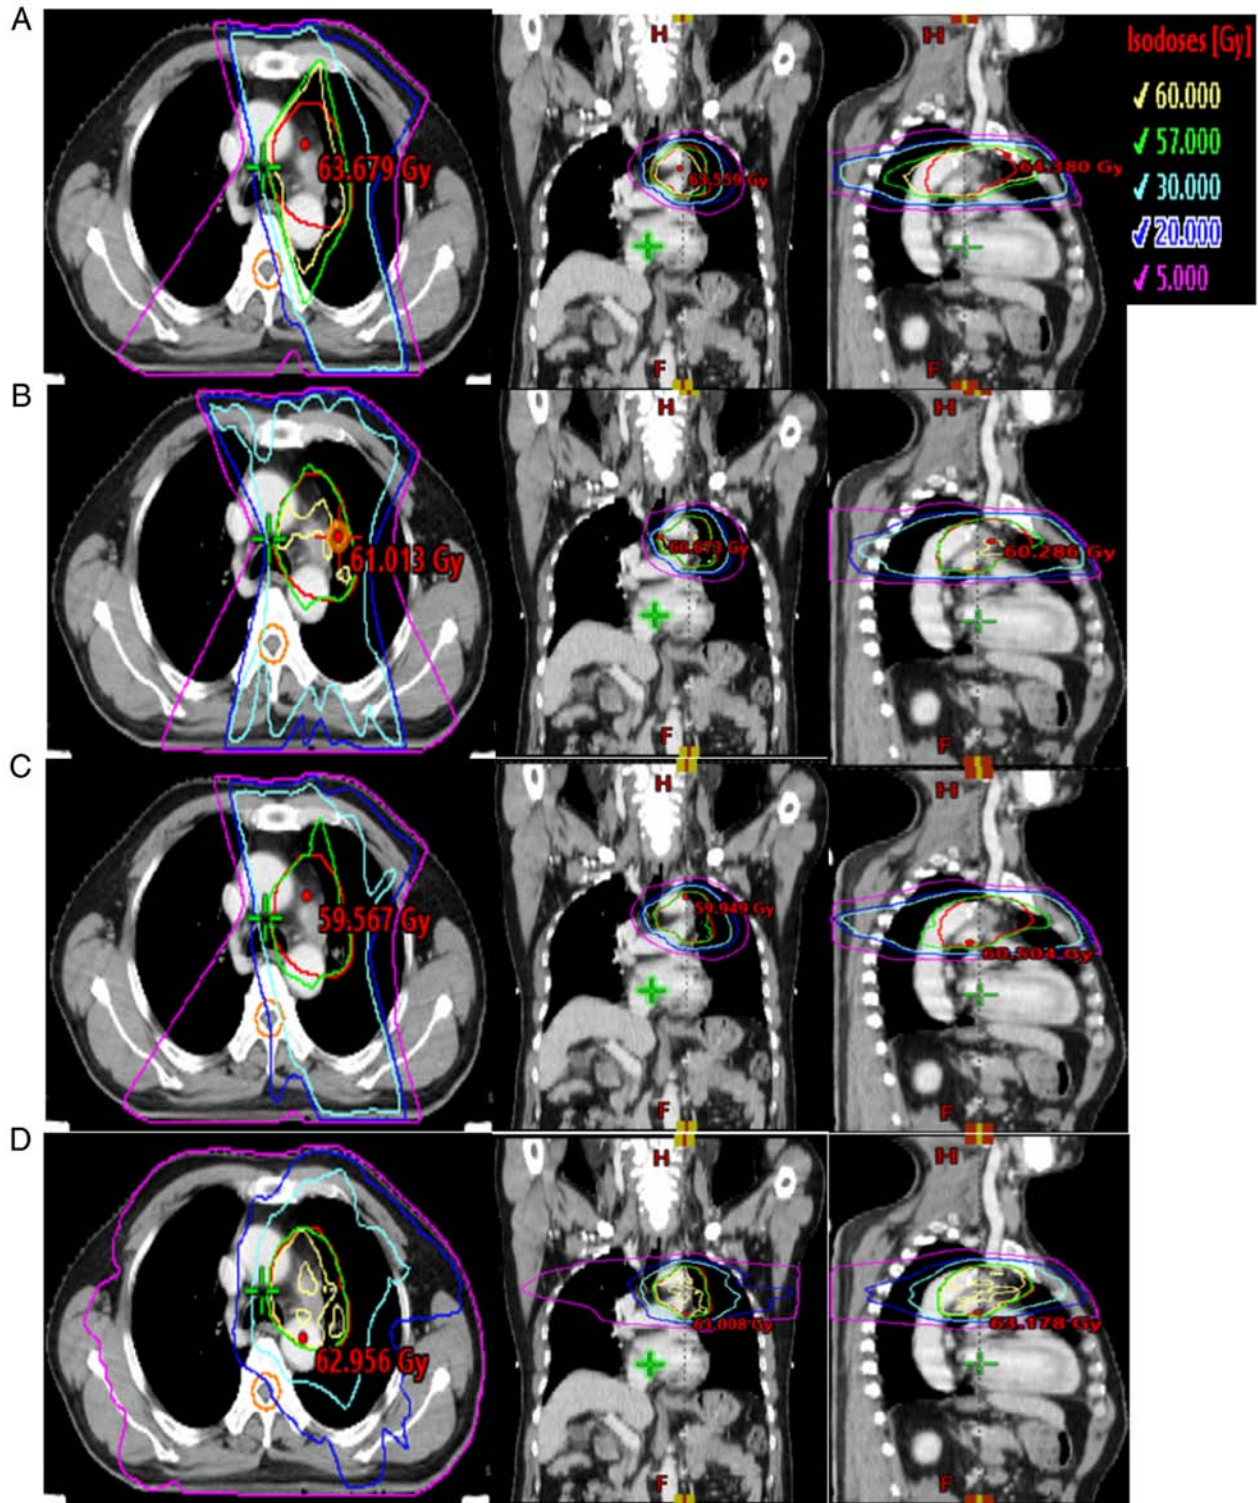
Typical isodose distributions for the four plans for a patient in the same computed tomography slice. (A) Three-dimensional conformal radiation therapy, (B) intensity-modulated radiation therapy, (C) hybrid intensity-modulated radiation therapy and (D) volumetric-modulated arc therapy. The red, blue, cyan, green and yellow lines represent the dose curves of 5, 20, 30, 57 and 60 Gy (i.e., the prescription doses), respectively.
